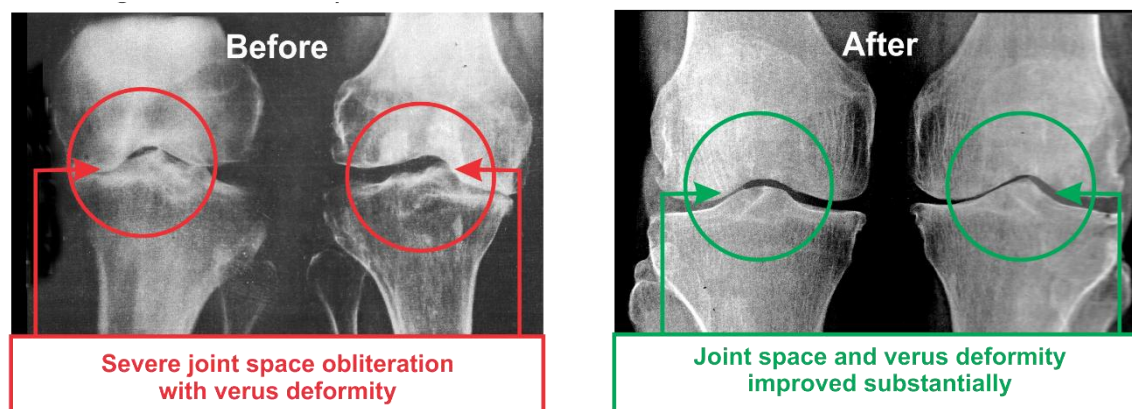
Radiographic images of before and after the treatment of knee joints
